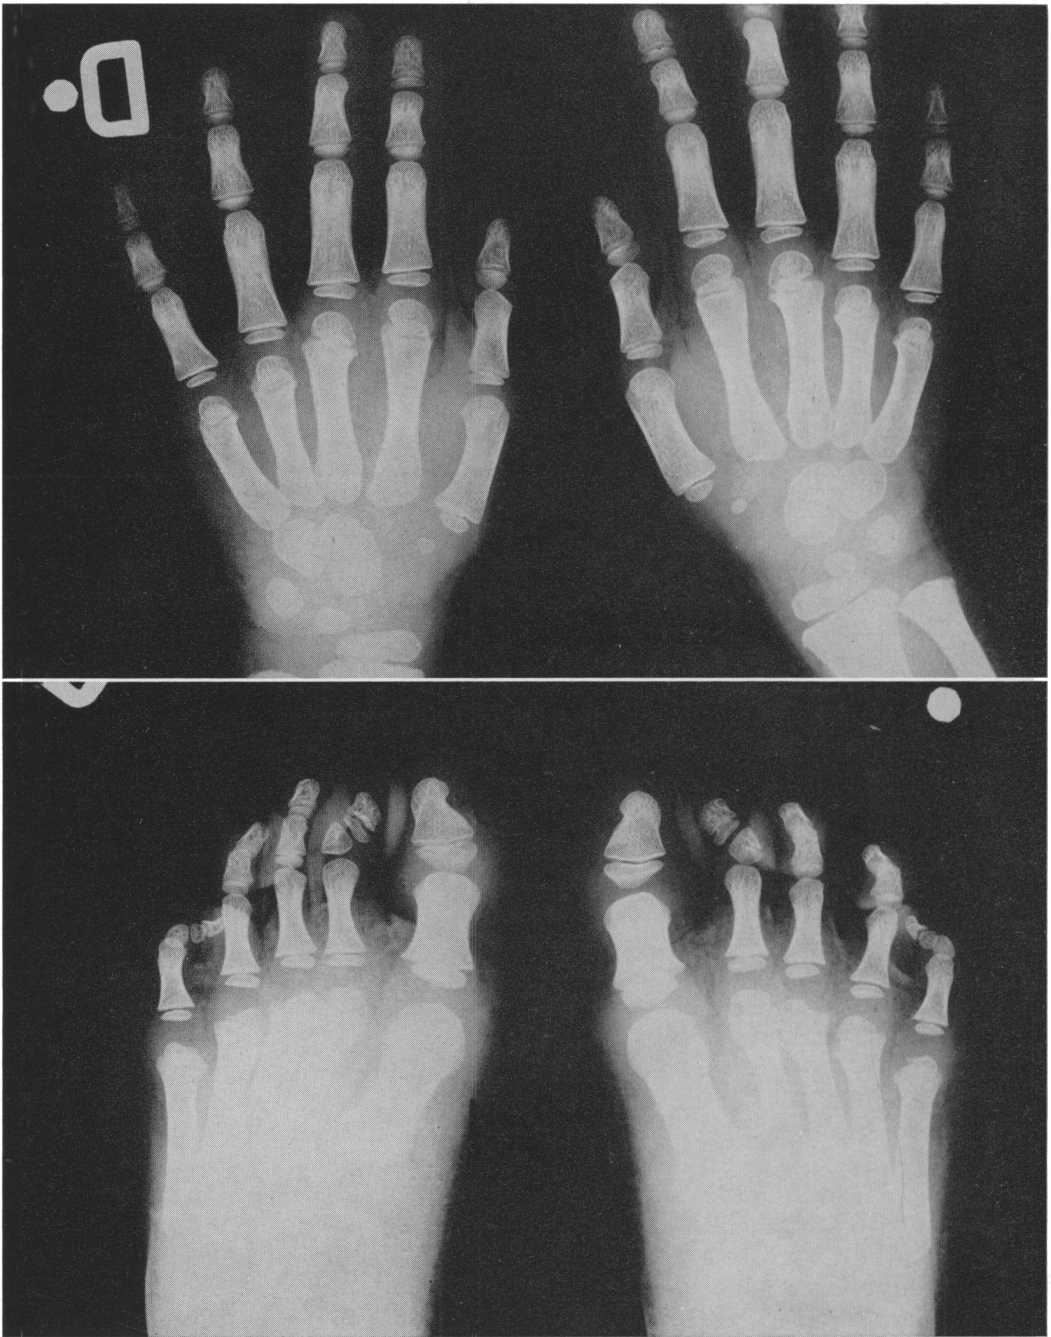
Roentgenograms of hands and feet of the same subject (IV,2) at age 5. The malformation is present only in the phalanges of second toes.
